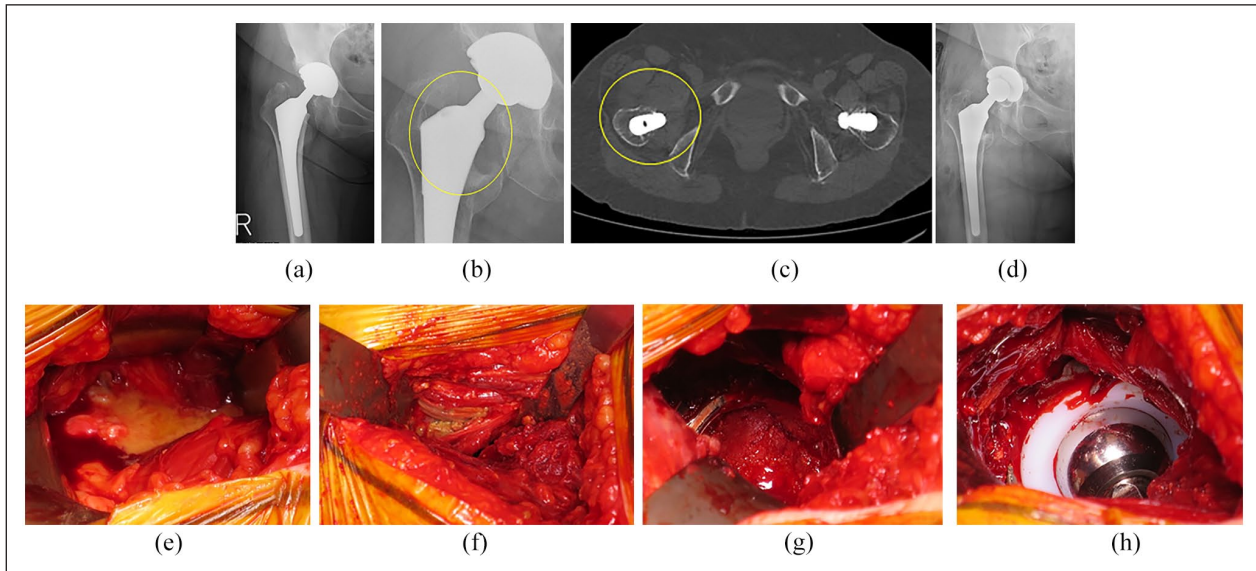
Postoperative radiography of a 59-year-old female patient who underwent MoM THA of the right hip using M2a Taper with head-size of 28 mm (a). The patient experienced no complications until 6 years postoperatively, when she developed right hip pain. At that time, focal osteolysis of the femur and the acetabulum were observed on radiography. A CT scan and radiography at 12 years postoperatively showed a pseudotumor around the stem and further advanced osteolysis at the femur (b) and (c). The patient subsequently underwent reoperation by changing the bearing surface to highly cross-linked polyethylene, and intraoperative findings were consistent with ARMD (d)–(h). (a) Postoperative X-ray. (b) X-ray performed 12 years postoperatively shows osteolysis (yellow circle) at the femur and acetabulum. (c) A CT scan performed 12 years postoperatively shows a pseudotumor (yellow circle) that developed around the proximal stem. (d) X-ray after revision surgery at 12 years from the THA. Intraoperative findings: (e) the capsule was filled with yellow-colored liquid; (f) a pseudotumor was filled with viscous debris inside; (g) the cup was filled with debris; and (h) after removing the debris, a highly cross-linked polyethylene liner was fixed with cement to the original metal cup, and the metal head was replaced to new one of the same-size.
